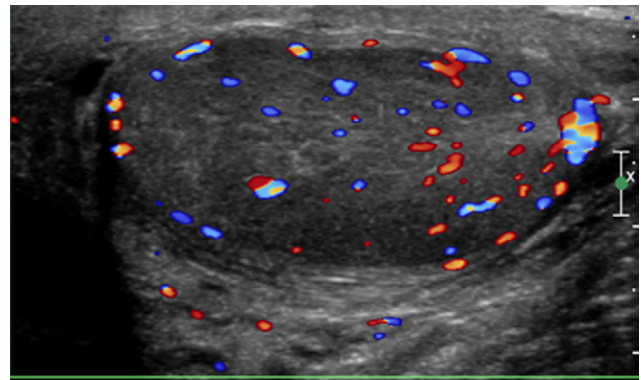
Epididymo-orchitis. Colour Doppler sonography: hyperaemia throughout the testicular parenchyma.
